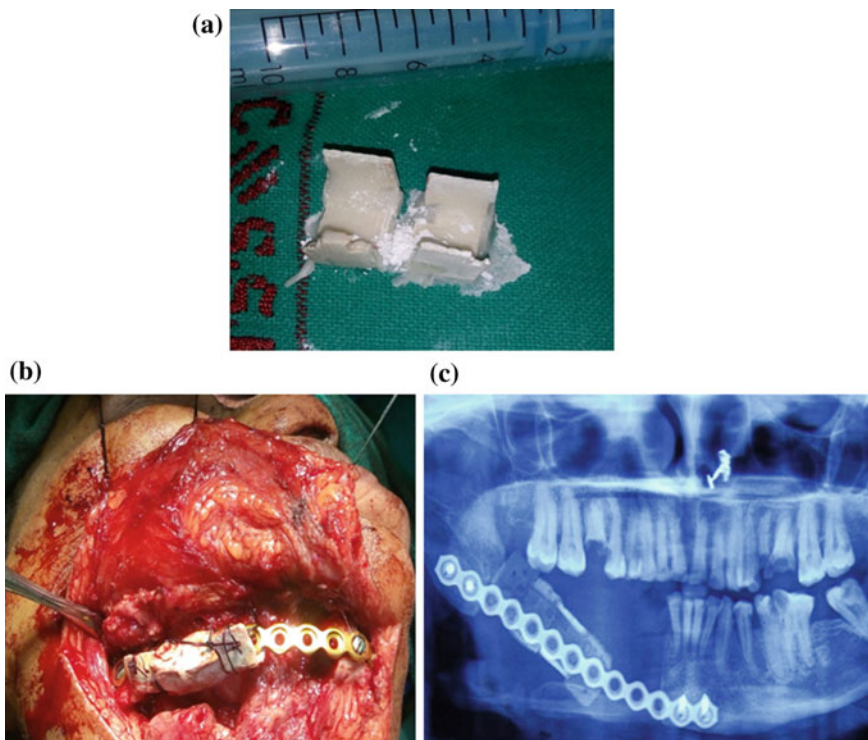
a 3D printed hydroxyapatite tray, b Per-operative photo showing custom made tray in situ, c Post operative OPG x-ray image of mandible after 6 months
